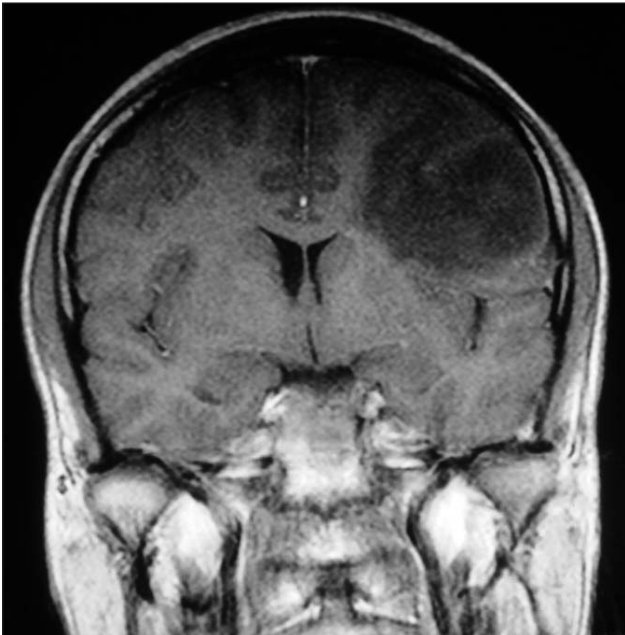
T1W MRI of sample case with no contrast enhancement and minimal mass effect.
